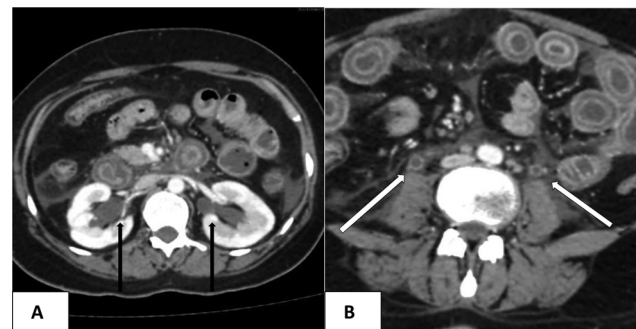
Axial sections of contrast-enhanced computed tomography (CECT) of the abdomen performed on the day of admission. (A) Bilateral hydronephrosis (arrows). (B) Hydronephrosis with urothelial enhancement (arrows).
